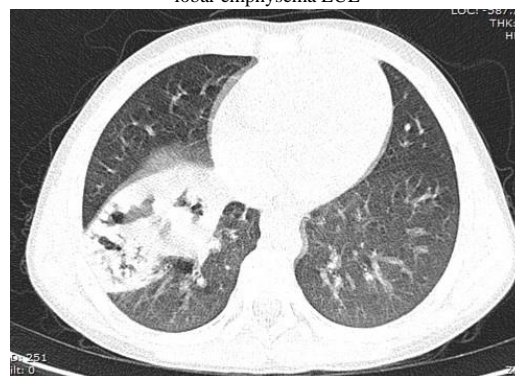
The CT scan showing CPAM in Right Lower Lobe.
